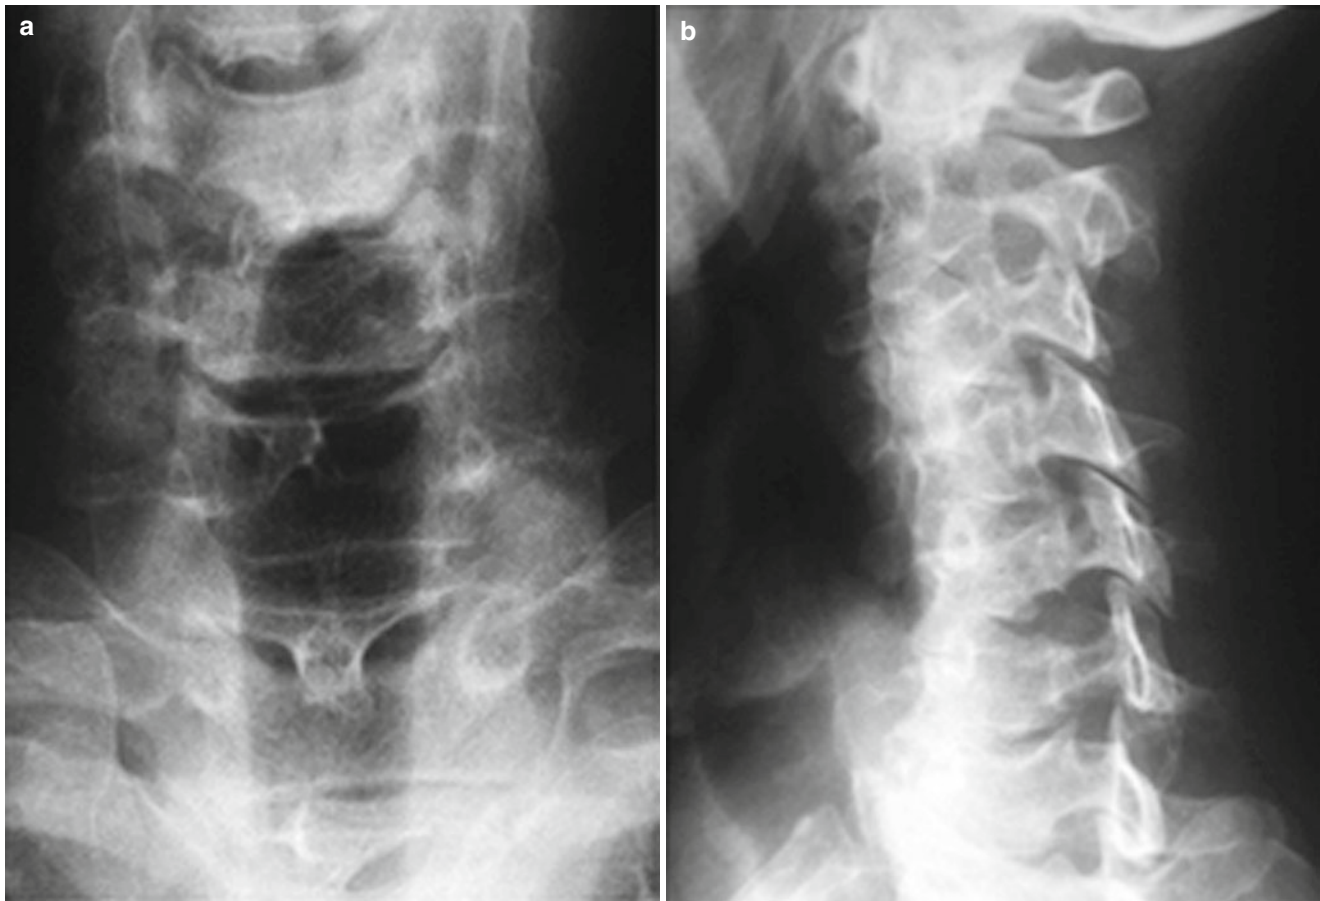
(a) Postoperative anterior-posterior and (b) oblique radiograph demonstrating completed right-sided anterior foraminotomy at cervical 5/6
